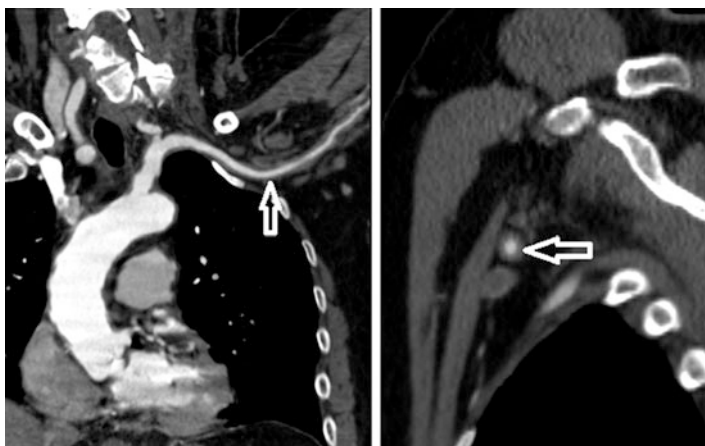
CT angiogram of a 64 year-old man with Giant cell arteritis showing wall thickening (arrows) of the left subclavian and axillary arteries (long axis, left image; short axis, right image) representing inflammatory changes in the acute phase. Normally, the arterial wall is not perceptible on CT angiography
